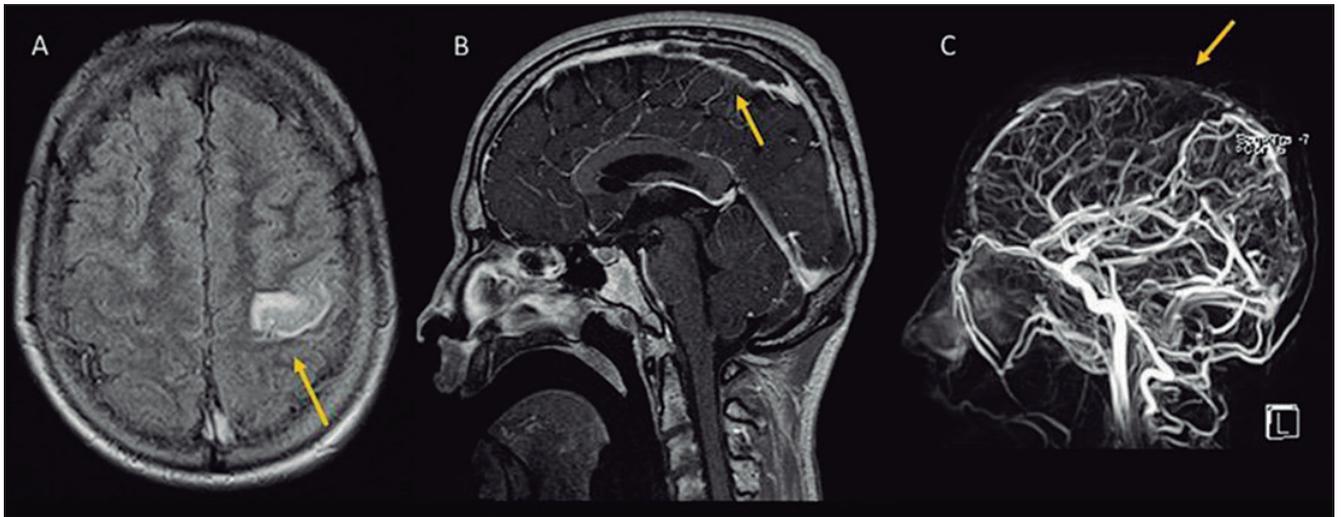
MRI of the brain of a fifteen-year-old patient with acute lymphoblastic leukemia. (A) Axial T2 FLAIR-weighted image show a hyperintense lesion concordant with a cortical ischemic stroke of the left postcentral gyrus. (B) Lateral sagittal gadolinium-enhanced T1-weighted image, and (C) MRV show signs of thrombosis of the middle and distal thirds of the superior sagittal sinus and adjacent cortical veins. A diffuse hypo intensity of the bone marrow compatible with infiltration by base pathology is observed.
